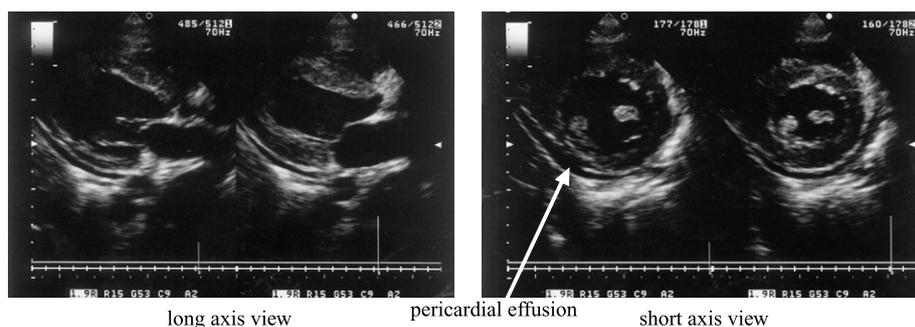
Transthoracic echocardiography. Echocardiogram showed mild degradation of the ejection fraction and mild pericardial effusion on hospital day 5.
